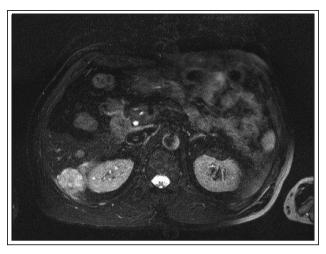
Superparamagnetic iron oxide-enhanced liver MRI demonstrating an enhancing mass on the liver concerning for a hepatocellular carcinoma.
